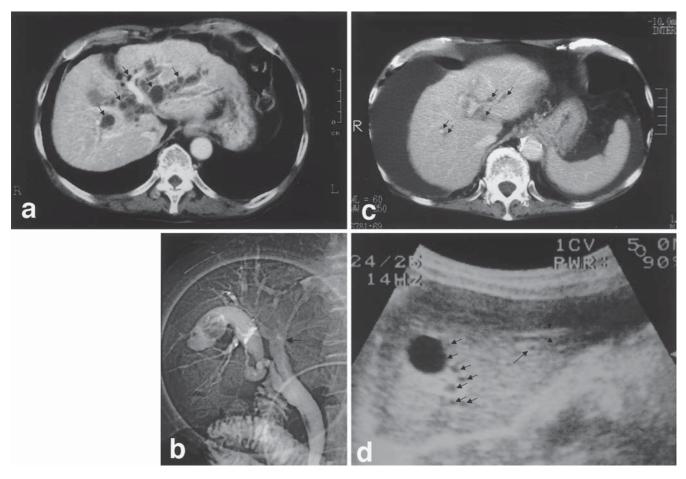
Imaging findings. a Computed tomography (CT) scan in case 1 revealed dilated intrahepatic bile ducts and multiple cystic lesions (*arrows*) in the hepatic hilum and large portal tracts. b Cholangiogram from endoscopic nasobiliary drainage (ENBD) tube in case 1 showed abrupt cutoff of the common hepatic duct (*arrow*), approximately 2 cm distal to the bifurcation of the cystic duct, and irregularity of the intrahepatic bile ducts. c CT scan in case 2 revealed multiple cystic lesions (*arrows*) in the hepatic hilum and large portal tracts. d Ultrasonography (US) in case 2 also demonstrated multiple cystic lesions (*short arrows*) in the hepatic hilum and large portal tracts. *Arrowheads*, bile duct; *long arrow*, portal vein
